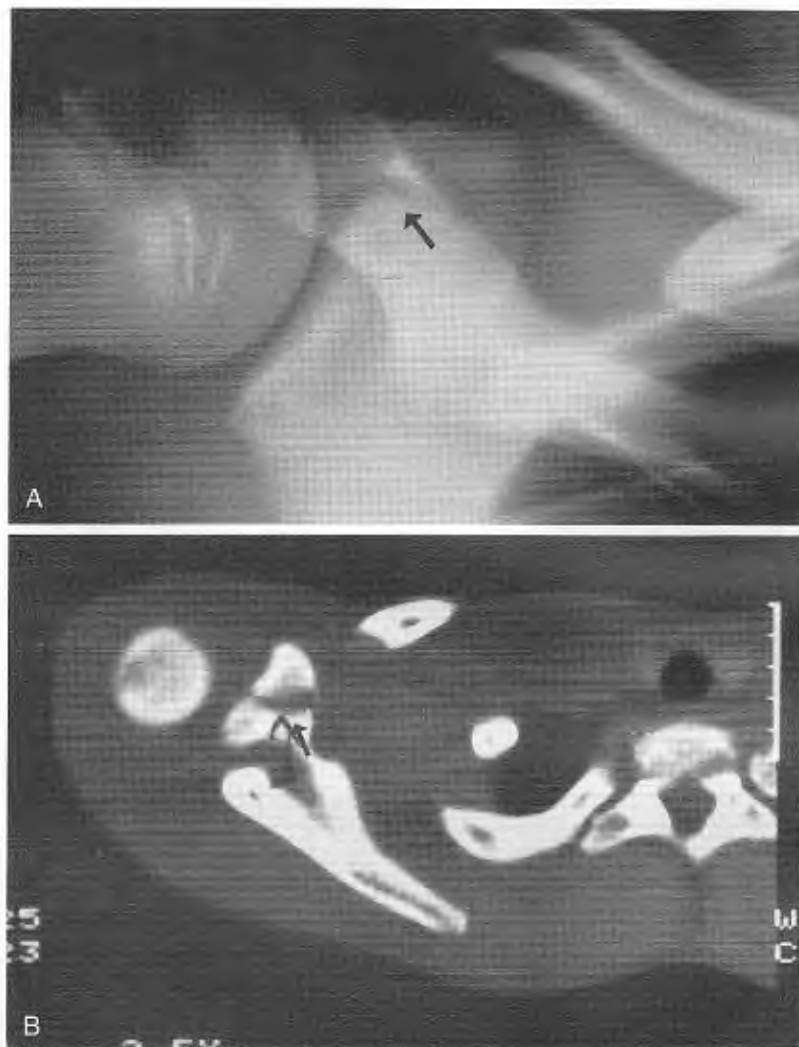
This patient sustained direct contact on the anterior aspect of his shoulder playing football and had tenderness directly over his coracoid. *A*, Stryker view of the right shoulder shows the fracture at the base of the coracoid (*arrow*). *B*, Computed tomography scan delineates the nondisplaced nature of the fracture (*arrow*). Healing occurred after 4 weeks in a sling and no contact for 12 weeks.
